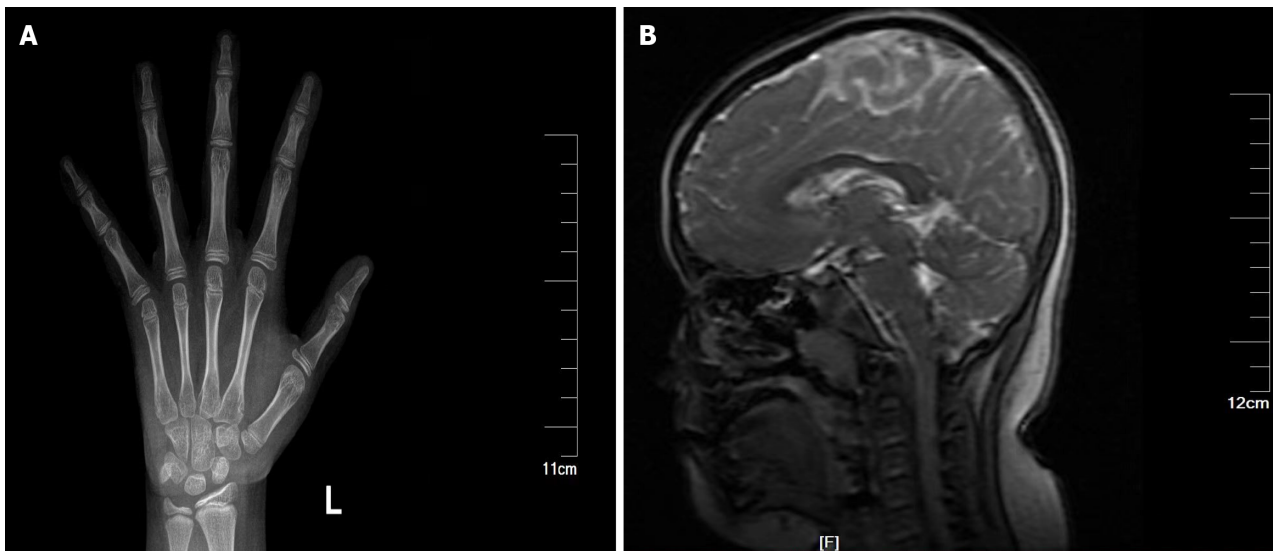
X-ray image of the patient's left hand and magnetic resonance image of the pituitary gland. A: X-ray image of the patient's left hand; B: Magnetic resonance image scans of the patient's pituitary gland.
